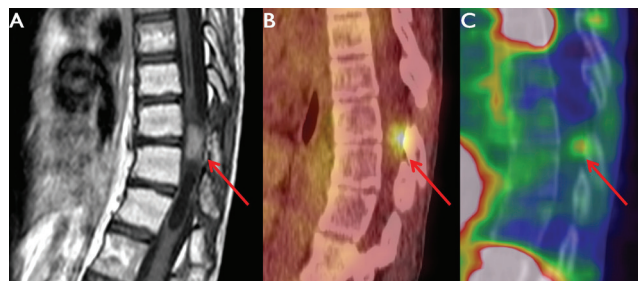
Tumour staging before vinblastine treatment. (A) T1-weighted turbo spin-echo magnetic resonance imaging. (B) Combined fluorodeoxyglucose positron-emission tomography and low-dose computed tomography. (C) Combined fluorothymidine positron-emission tomography and low-dose computed tomography. Corresponding transverse slides show high uptake of both fluorodeoxyglucose and fluorothymidine in an intramedullary localized tumour.
